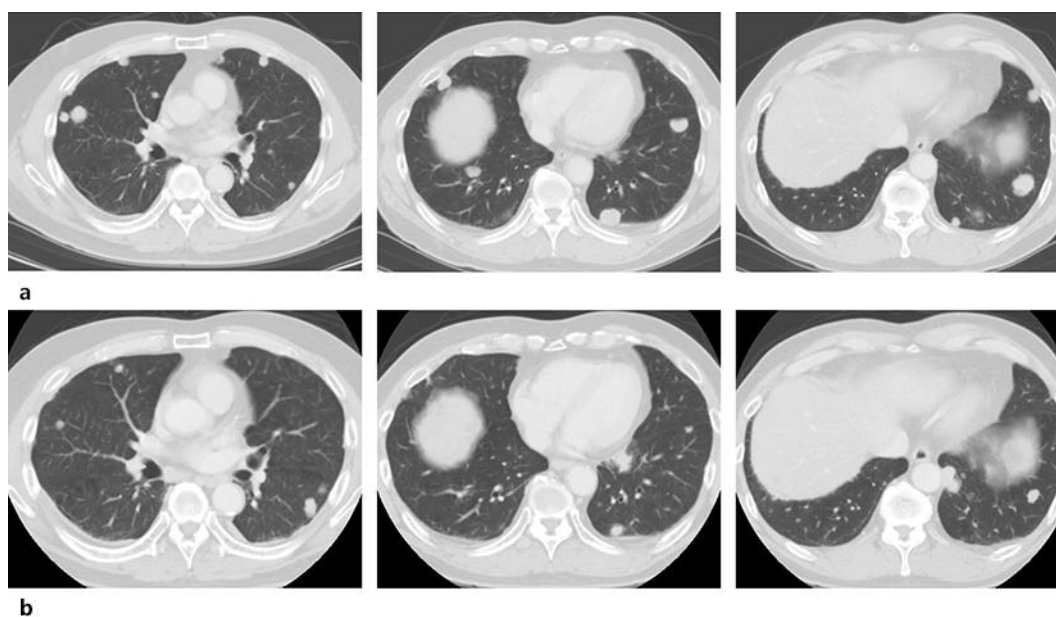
Chest computed tomography image before starting panitumumab (a) shows multiple pulmonary metastatic lesions in the bilateral lungs. b After 2 months of panitumumab treatment, the pulmonary lesions had been markedly reduced and a portion of the lesions had disappeared.
